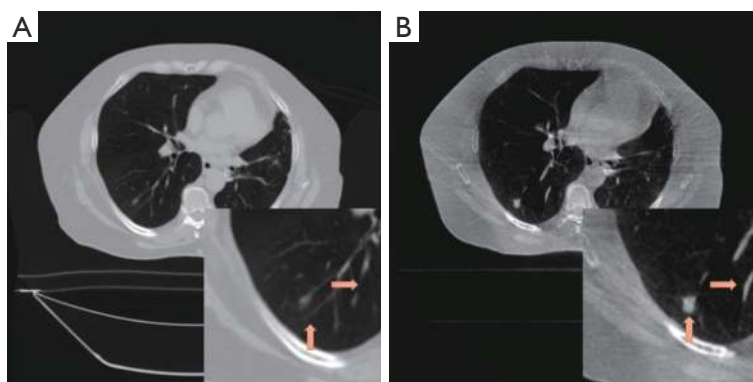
An example of the mismatch when deforming the prior CT image. (A) is the deformed prior CT image and (B) is the on-board full sampling CBCT images. Tumor region is zoomed in as shown in the right down corner in each image to show the mismatch because of deformable registration errors as pointed out by arrows. CBCT, cone-beam computed tomography.
